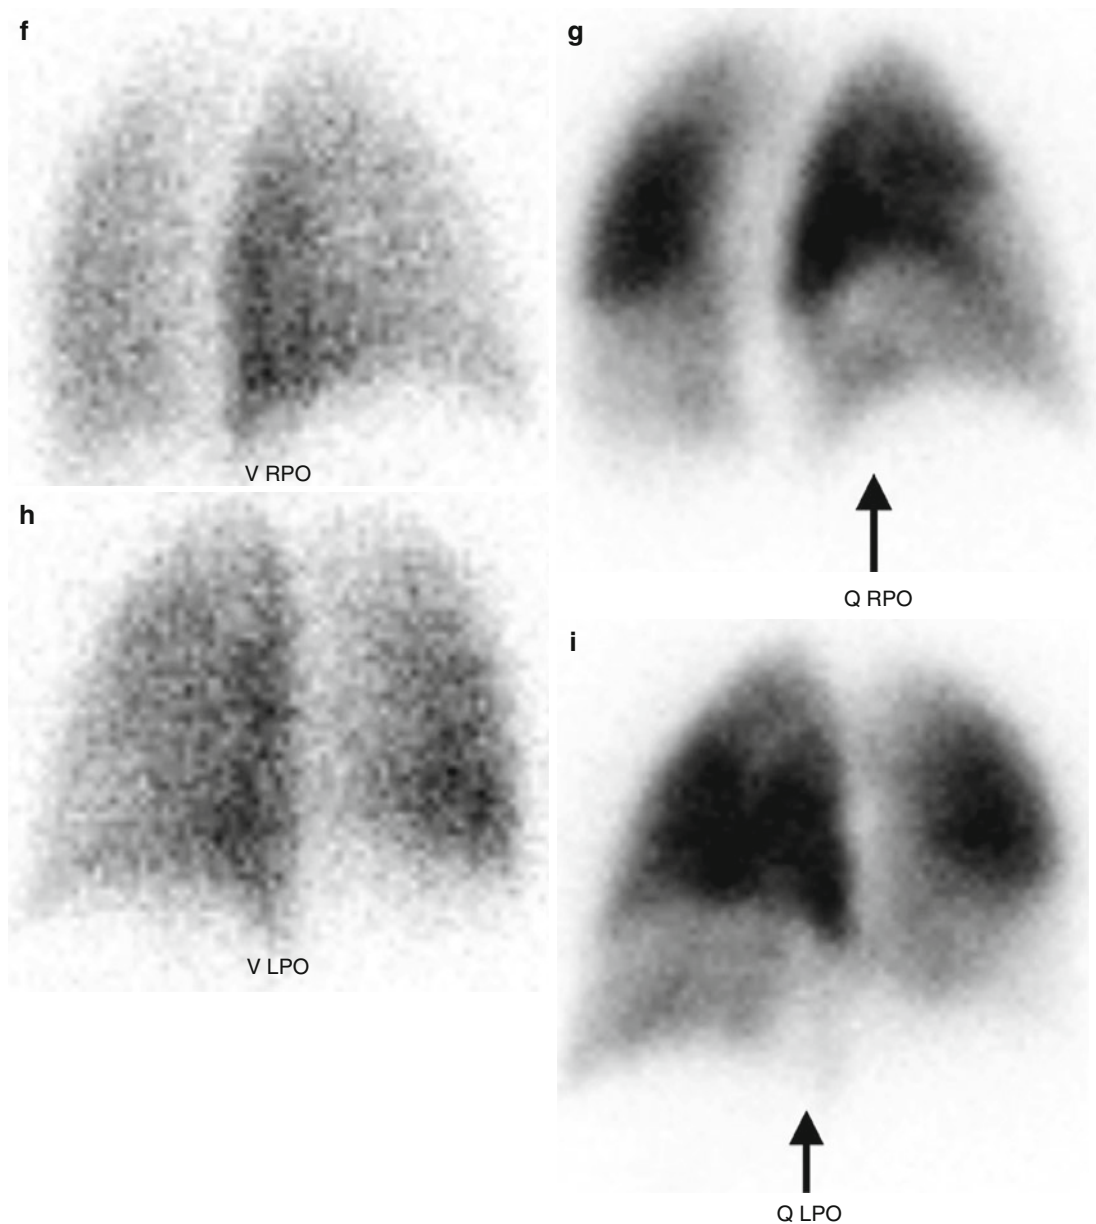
High probability for acute PE (multiple V/Q mismatches). Normal chest radiograph (a). Normal ^{99m}Tc DTPA ventilation (left panel: b, d, f, h) and abnormal ^{99m}Tc MAA perfusion (right panel: c, e, g, i) with multiple bilateral lower lobe segmental perfusion defects (arrows)
